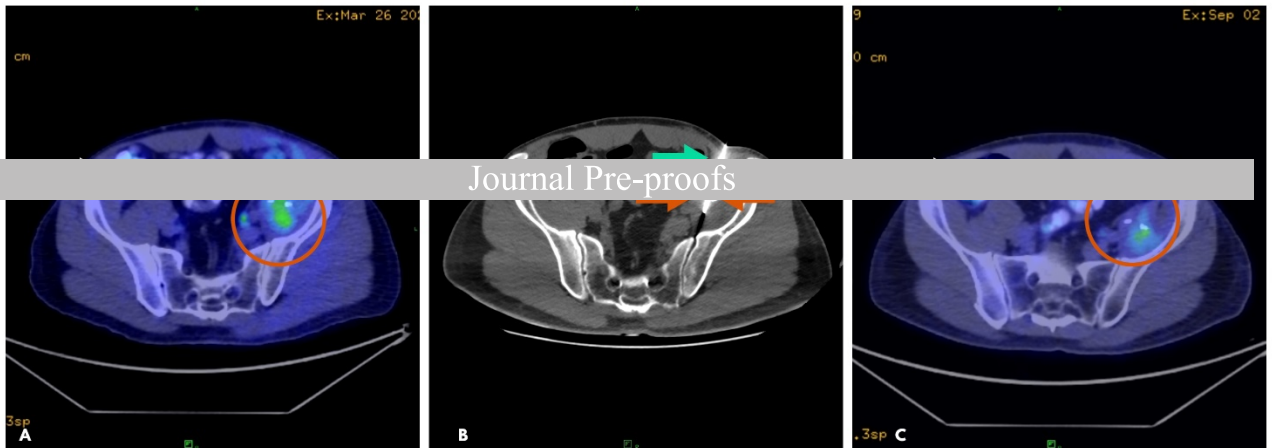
A: 18F-FDG-PET CT identical axial slices of remnant (remaining tumour tissue after surgery) myofibroblastic sarcoma before VEG ECT and C: after VEG ECT- tumour designated with red circle. B: NEC (non-contrast enhanced) CT for VEG electrode placement (green arrow) and metal clips placed as a hallmark for tumour margins during previous surgery (orange arrows). White arrows indicate physiological accumulation at the site of the coecum (A, C). Tumour volumes- A: preECT: 131.13 cm³, C: postECT: 86.78 cm³; volume change: -33.82% confirming partial response (PR) to treatment. Total lesion glycolysis (TLG) is a value that characterizes the complete size of the metabolically active tumour, which was calculated as metabolic tumor volume (MTV) multiplied by the mean standard uptake values (SUV): preECT TLG : 251,21 g, postECT TLG: 178,97 g. VEG: variable electrode geometry; ECT: electrochemotherapy
